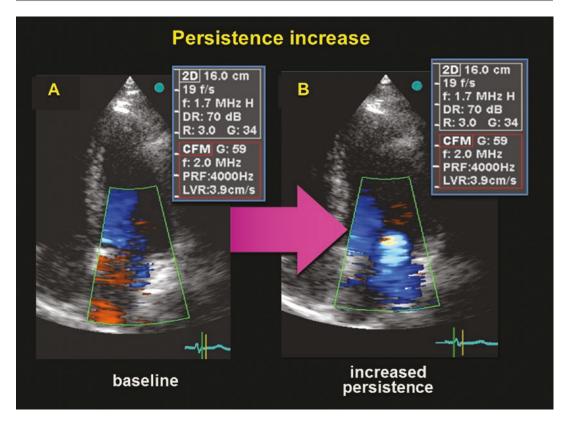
Image persistence may also increase the size of a jet and have no place in echocardiography for examination of the rapidly moving heart
